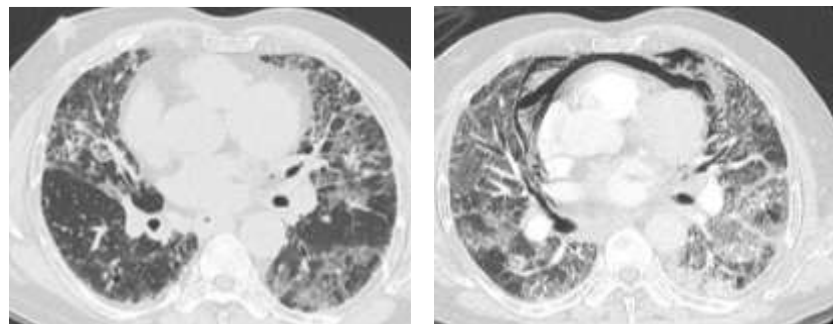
HRCT(A) and CTPA (B) at the level of pulmonary trunk showing pneumomediastinum in CTPA
